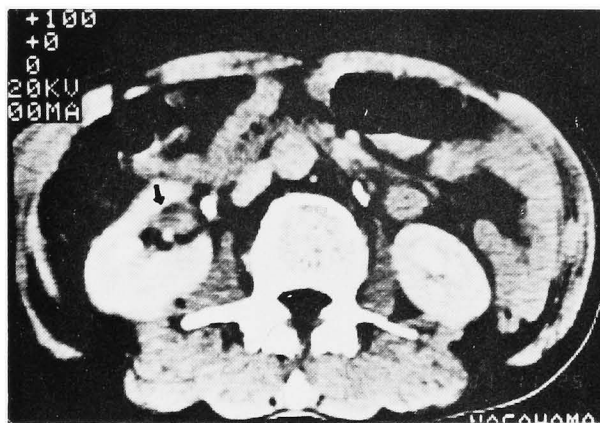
Case 1—Computed tomography demonstrates a well-defined mass in the right renal pelvis (arrow). The mass was not enhanced with contrast medium.
